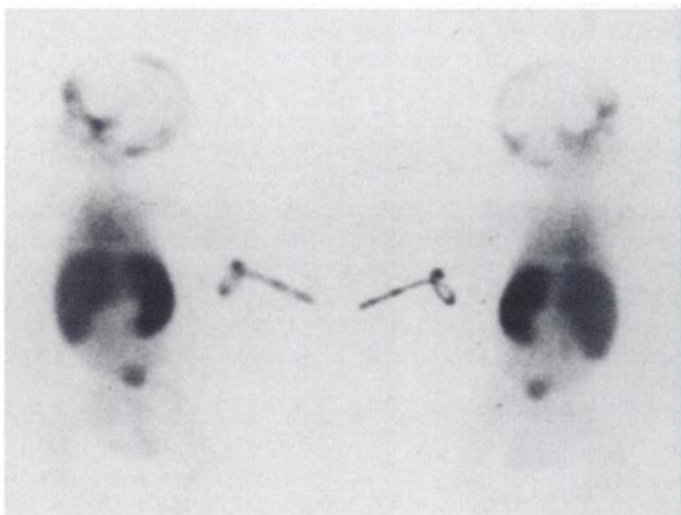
Bone marrow immunoscintigraphy with ^{99m}Tc -labeled anti-NCA 95 antibodies 4 hr postinjection shows hematopoietic bone marrow in skull base and areas of extramedullary hematopoiesis in liver and spleen.
